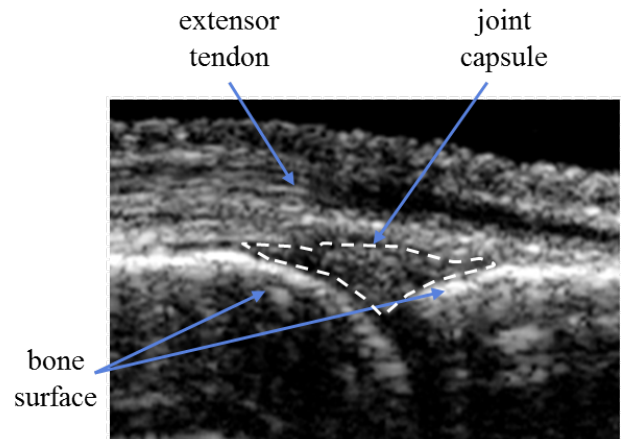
Sonographically observed anatomy of a Metacarpophalangeal (MCP) joint (derived from [10]).
